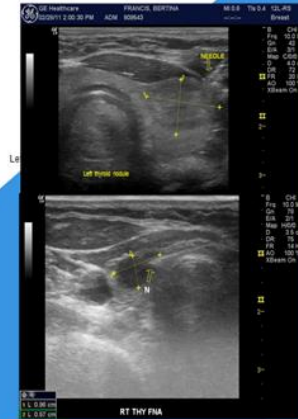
Ultrasound Guided FNA Biopsy of Thyroid
